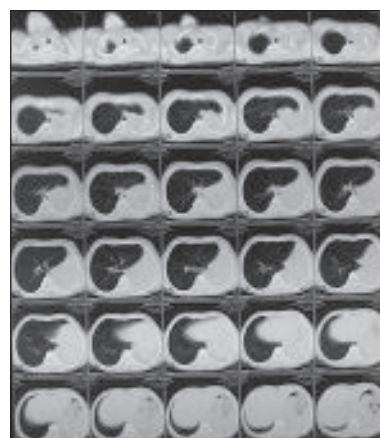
Pulmonary aplasia: CT scan image on lung window shows hyper expanded right lung gaining access into the left hemithorax secondary to left pulmonary aplasia. Left main bronchus is clearly visualized differentiating it from pulmonary agenesis.*
